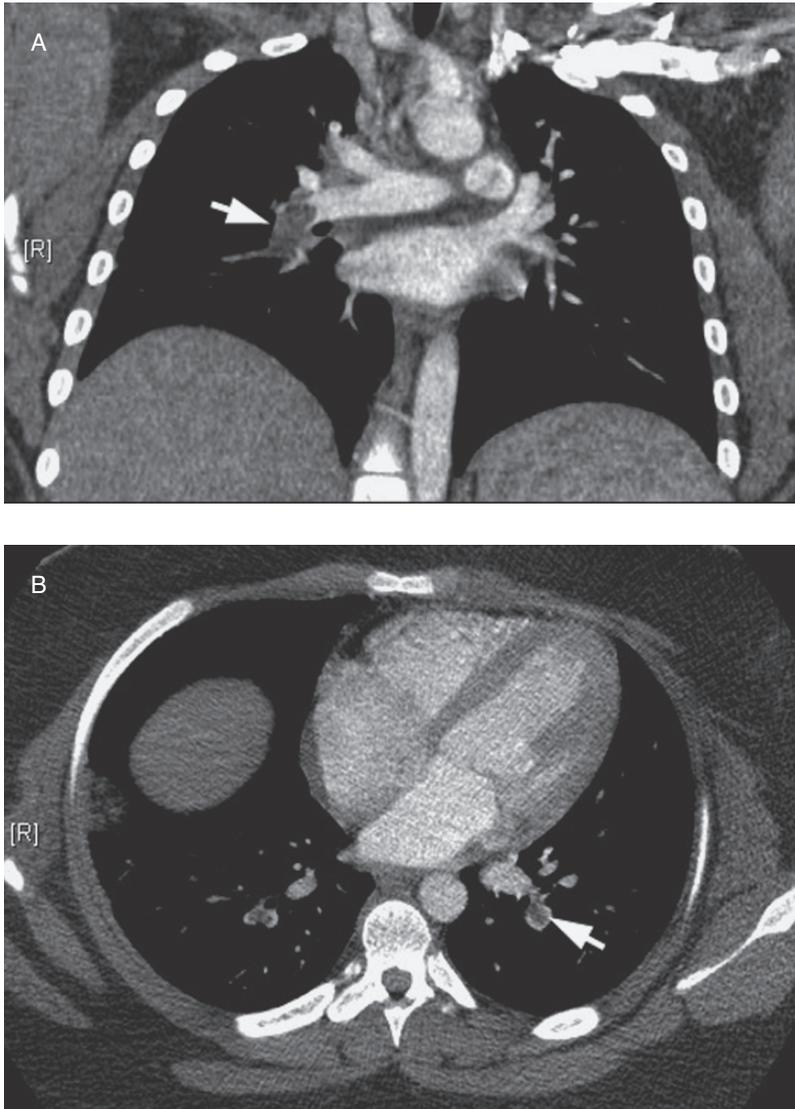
CT angiogram (CTA) of pulmonary embolus. (A) Coronal reconstruction of CTA demonstrates the large right lower lobe pulmonary artery embolus (arrow) outlined by contrast media. (B) Transaxial CTA image demonstrates bilateral lower lobe pulmonary emboli, with prominent left lower lobe embolus (arrow) clearly outlined with contrast media.
